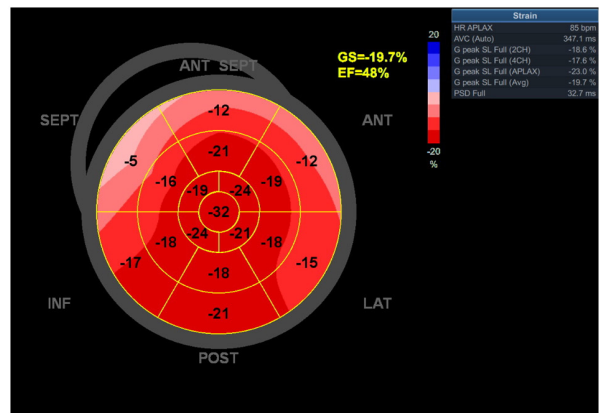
Echocardiography bull's-eye plot at the initial evaluation showing a slightly reduced global strain and ejection fraction, localized at the level of the basal segments of the antero-lateral, antero-septal and septal walls and interventricular septum. SEPT, septal wall; ANT, anterior; LAT, lateral wall; POST, posterior; INF, inferior; GS, global longitudinal strain; EF, ejection fraction; AVC, aortic valve closure; HR, heart rate; APLAX, apical long-axis; PSD, peak strain dispersion; G peak SL, global peak longitudinal strain.
